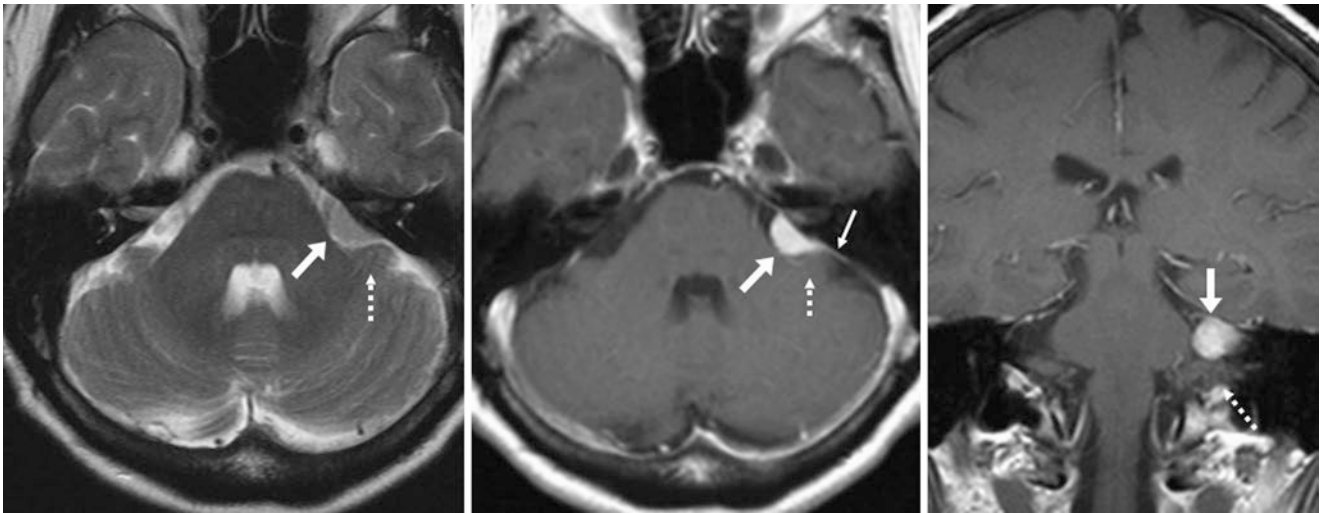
Comparison case of a CPA meningioma: a 70 year old with left-sided hearing loss had an extra-axial mass (arrows) within the left CPA on a 1.5 T T2WI MRI (left), which enhanced on postcontrast axial
